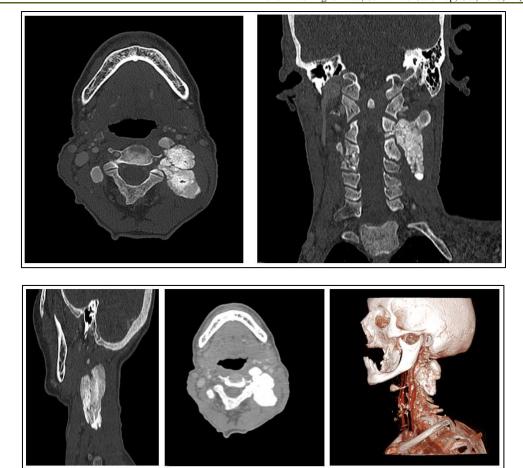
cervical CT scan in axial, coronal and sagittal planes, and in 3D reconstruction, with and without enhacenemnt showing a left latero-cervical voluminous mass, which extends from C1 to C4, over a length of 5 cm, with an endoforaminal extension C2-C3, and compresses the vertebral artery at this level which remains permeable.
